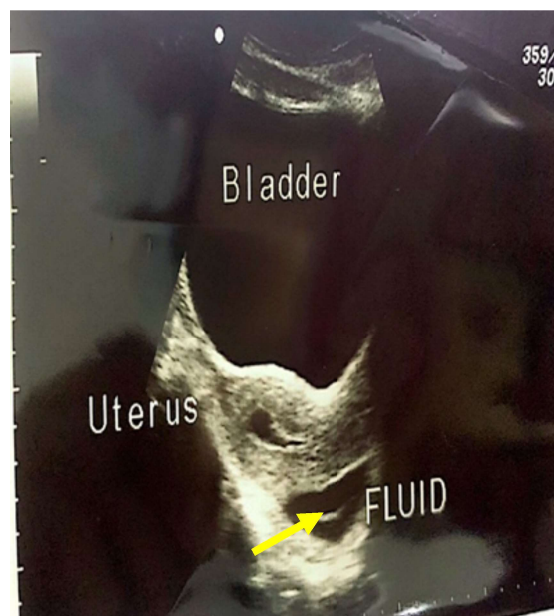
Transabdominal pelvic ultrasound scan revealed an intrauterine copper device (IUCD) (arrow) in the pouch of Douglas.
